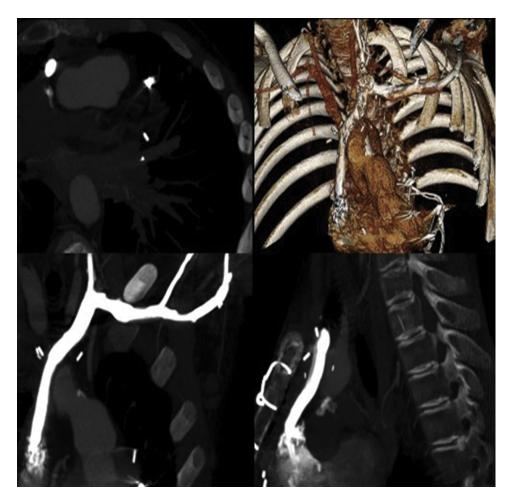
Computed tomographic (CT) angiography shows patent innominate vein-to-atrium conduit.
